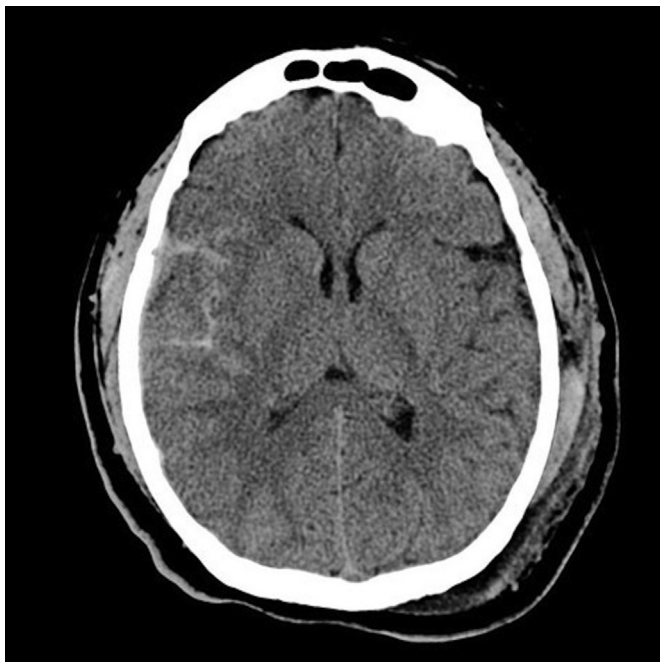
Axial noncontrast head CT scan, traumatic subarachnoid hemorrhage within the right Sylvian fissure with a contusion. Source: Reproduced from Radiopaedia.org, rID:4852, case courtesy of Assoc Prof Frank Gaillard, under the Creative Commons Attribution BY-NC-SA 3.0.
